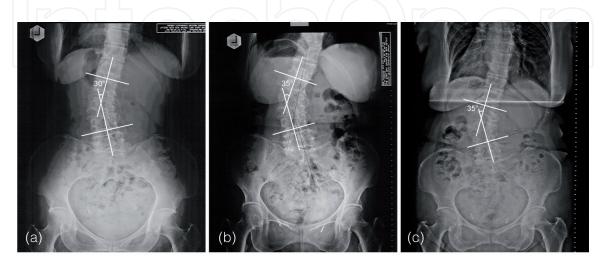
Progression of degenerative lumbar scoliosis in a postmenopausal woman 70 years of age. In the year 2003 (a), the left lumbar scoliosis measured 30°. It increased to 35° in year 2009 (b). After the patient was prescribed Fosamax by his medical practitioner, the curve stabilized, as can be seen in the radiograph in 2017 (c).
